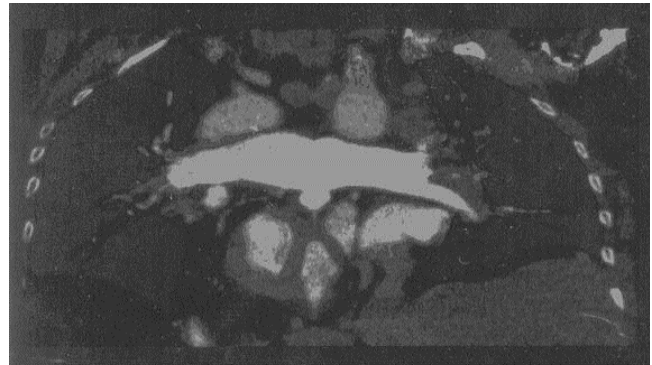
Contrast computed tomogram of chest showing presence of filling defect in left main pulmonary artery.
